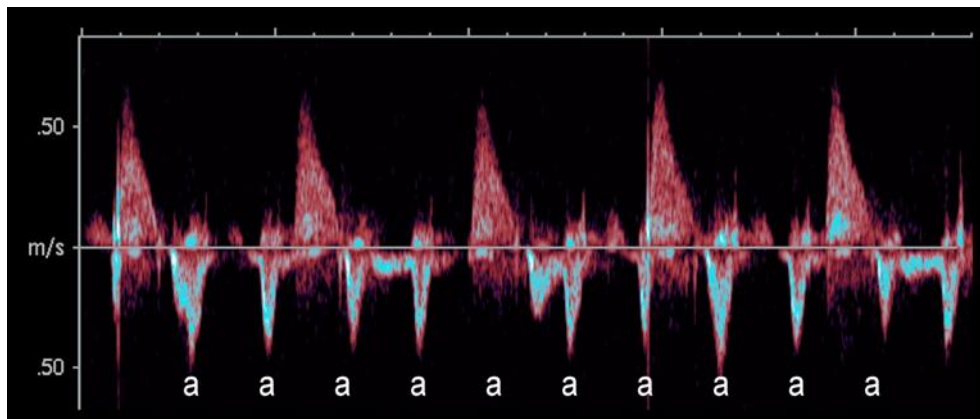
A Doppler recording from the left ventricular in- and outflow tract (MV-Ao) showing a complete heart block and atrioventricular dissociation with the superiorly directed slower ventricular outflow and the faster, inferiorly directed inflow, with the A waves marked (a), sometimes not clearly visible during ventricular systole
